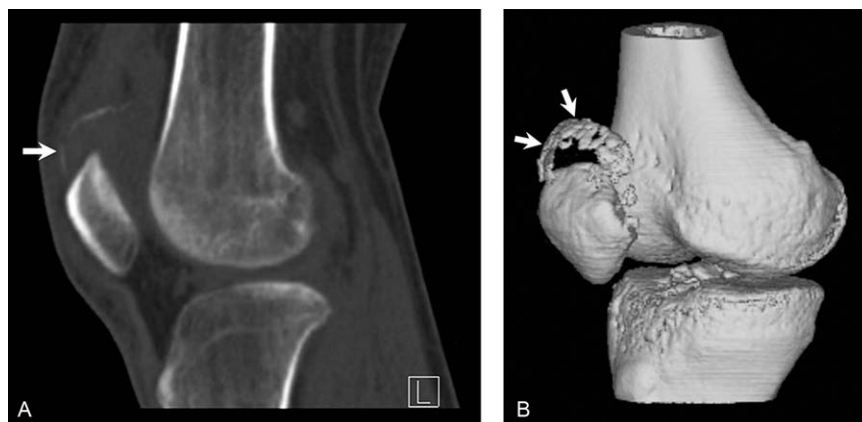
On computed tomography (CT) images, a shell of bone lying proximally to the patella is showed on multiplanar reconstruction (A) and shaded surface display images (B).
